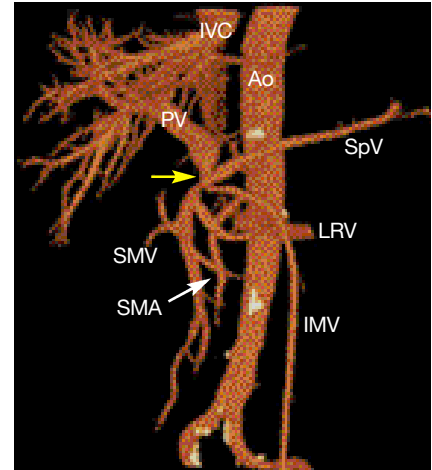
CT angioportography with three dimensional reconstruction of the portal vein showing tumour invasion at its origin (yellow arrow).
